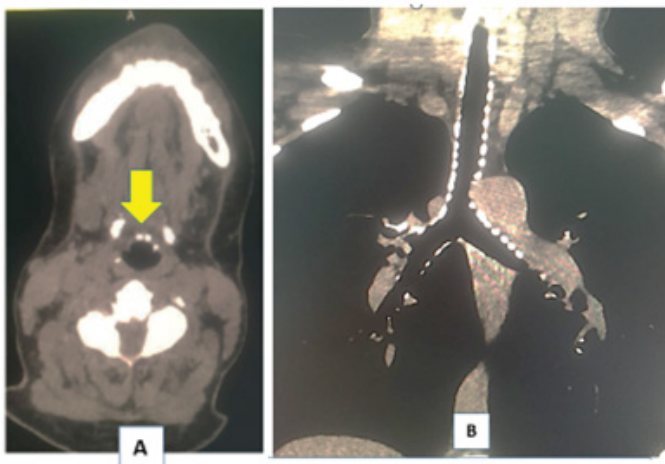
Computed tomography scan images showing extensive calcifications extending from the subglottis (A, arrow) to the trachea and bronchial tree (B).
